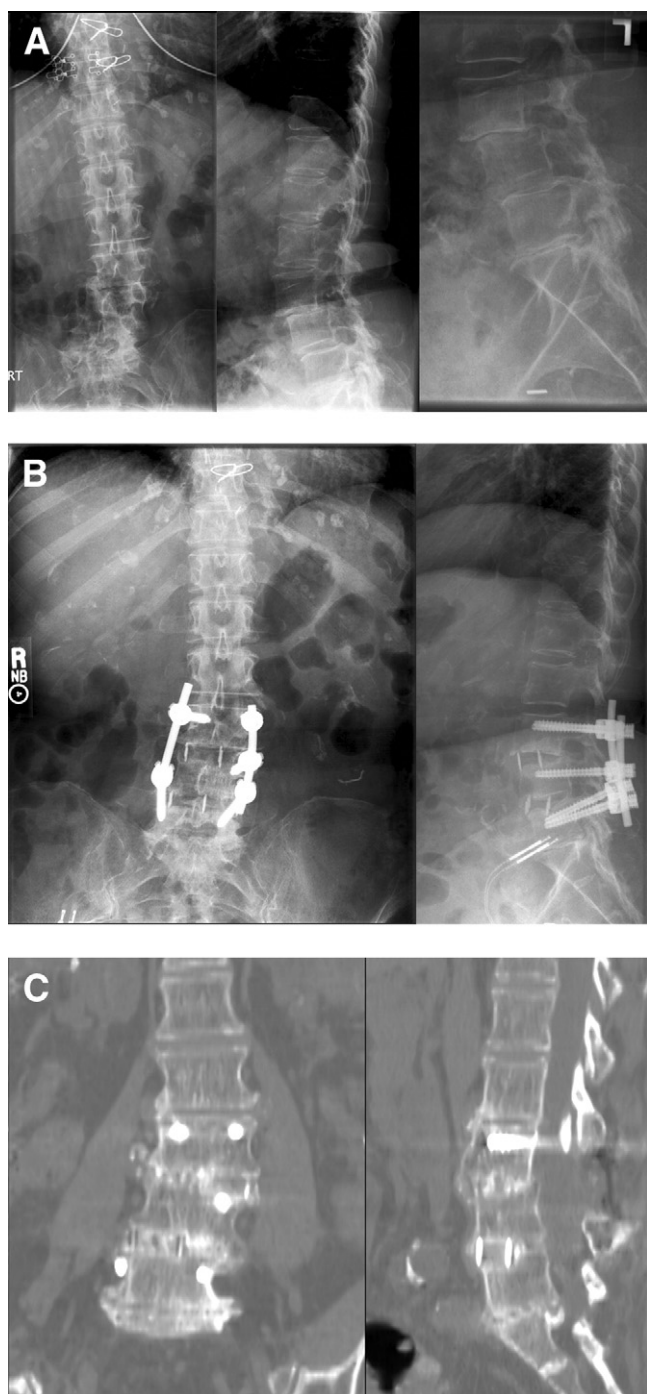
Preoperative (*top*) radiographs, immediate postoperative (*middle*) radiographs, and 24-month (*bottom*) CT scans of a 68-year-old female anteriolateral fusion patient treated for degenerative spondylolisthesis and scoliosis. Note increase in disk height, correction of coronal and sagittal alignment, and maintenance of corrections as well as bridging bone in 24-month images.
